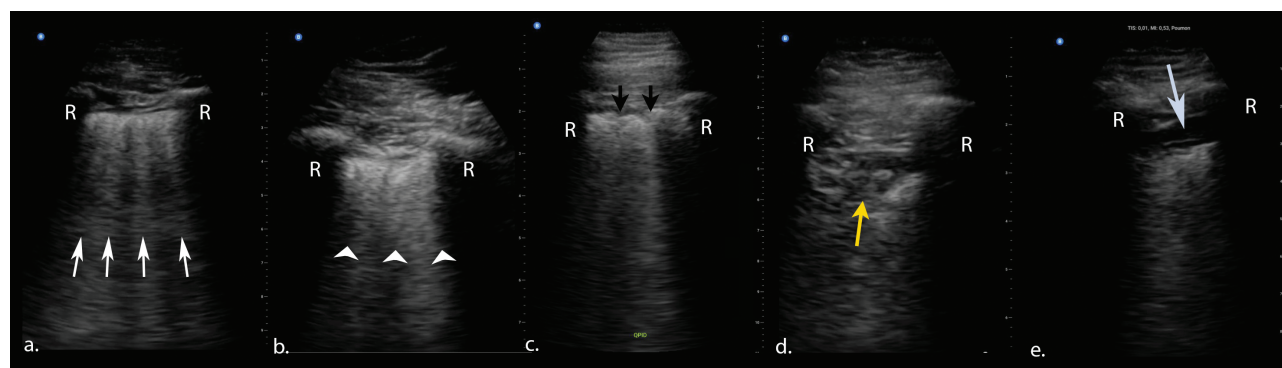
Pathological patterns of lung ultrasound observed in COVID-19, with a convex probe and a large field of view, on sagittal scans. Rib shadowing (R) is visible on the sides of the images. *A*, Four B lines (small white arrows) spreading out from the pleural surface. *B*, Confluent B lines (white arrowheads) shaping a curtain covering the depth of the image (white lung). *C*, Thickening of the pleural line with small (< 1 cm) irregularities (small black arrows). *D*, Large consolidation (> 1 cm) (yellow arrow). *E*, Small pleural effusion (large white arrow) forming a hypoechoic line between the thoracic wall and the lung.
